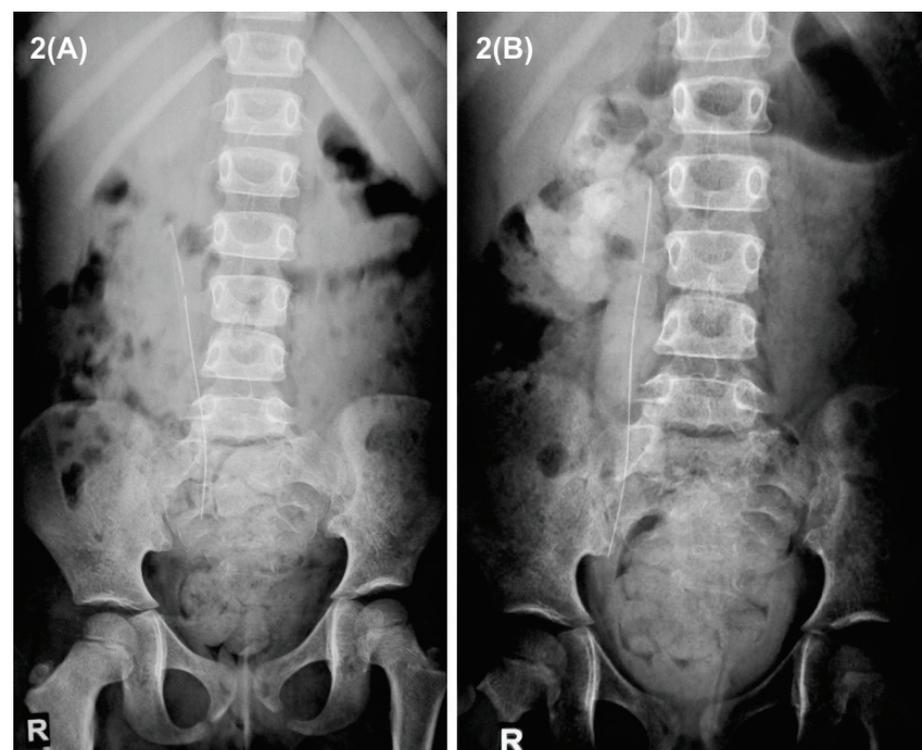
X-ray and intravenous pyelogram showing (A) upper end of feeding tube in pelvis and (B) lower end in ureter.
